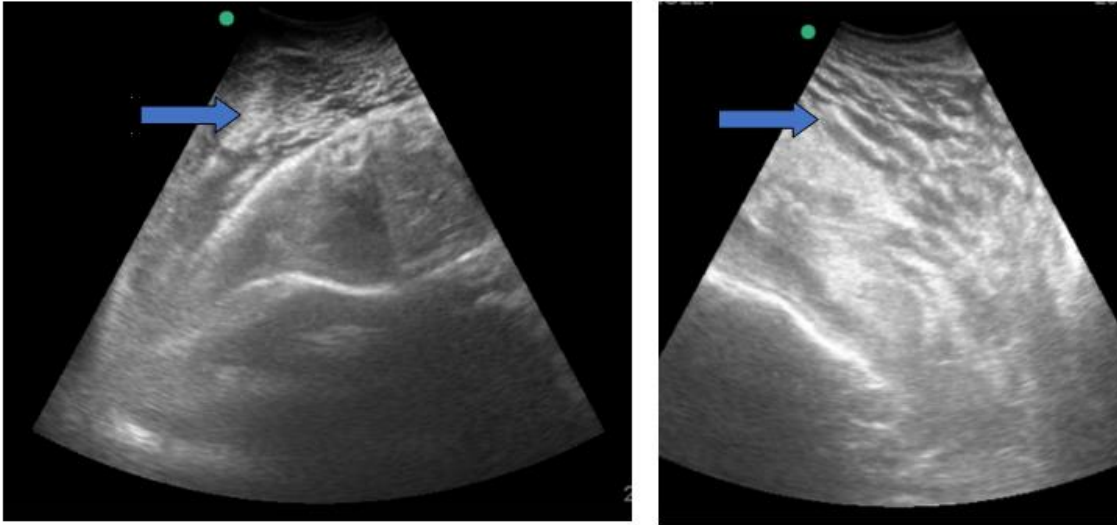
Ultrasound images of ventral swelling using 5-2MHz convex probe. Blue arrow indicates edema. Green dot indicates cranial.
